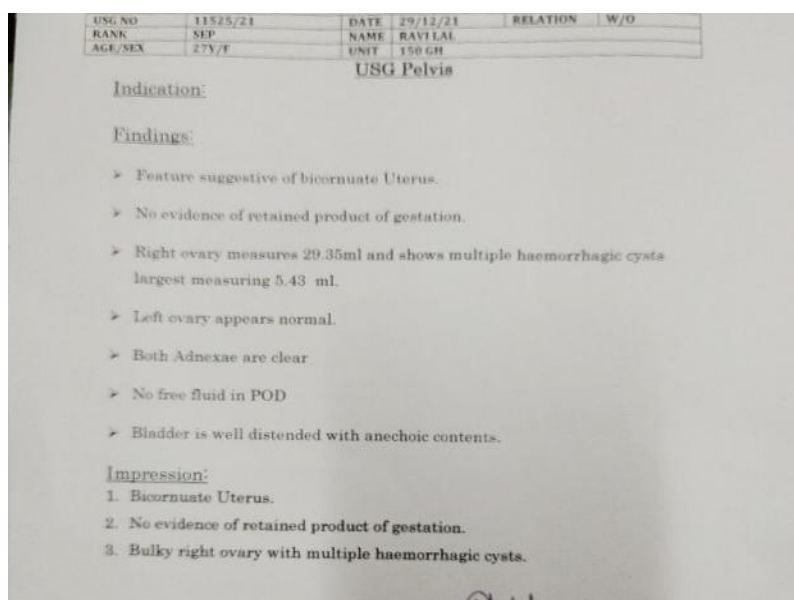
Post-operative follow up ultrasonography report
